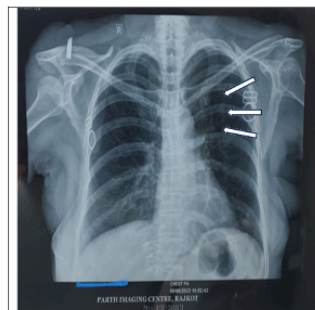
chest radiograph dated on 09/06/23
